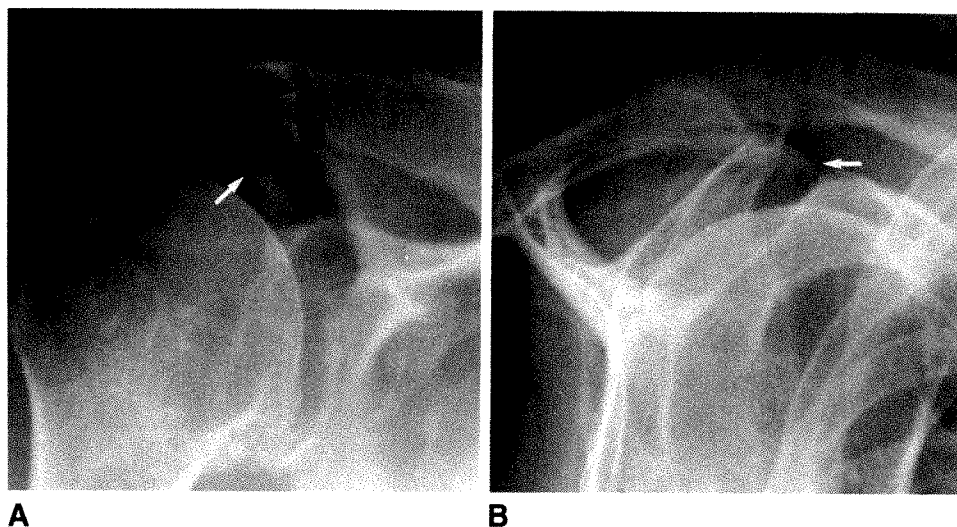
A and B, Radiographs show appearance of subacromial spur (arrows) on 30° caudally angled anteroposterior view (A) and on supraspinatus outlet view (B).
